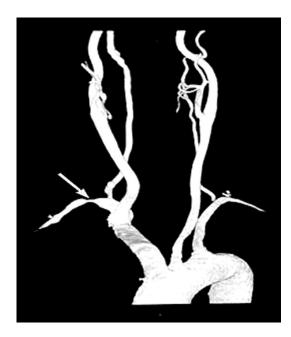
Head and neck computed tomography angiography showed right subclavian artery proximal stenosis, with narrowing of about 70%.
